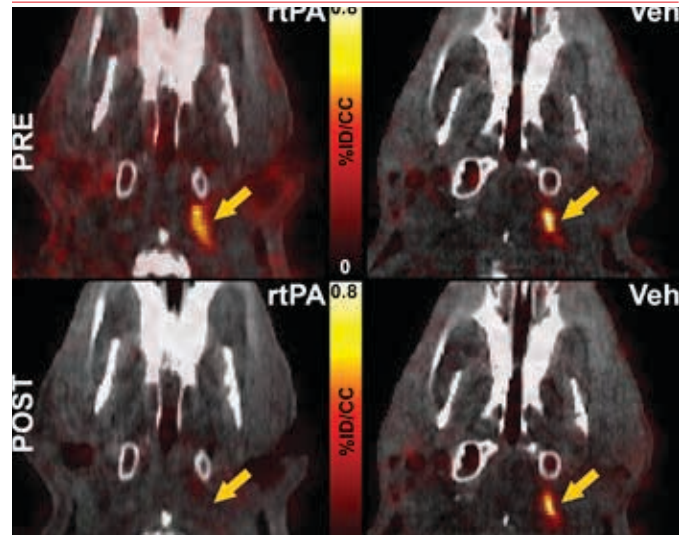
FBP7 Detects Mural Thrombosis at the Level of the Common Carotid Artery (arrow). Fused PET-CT image.
